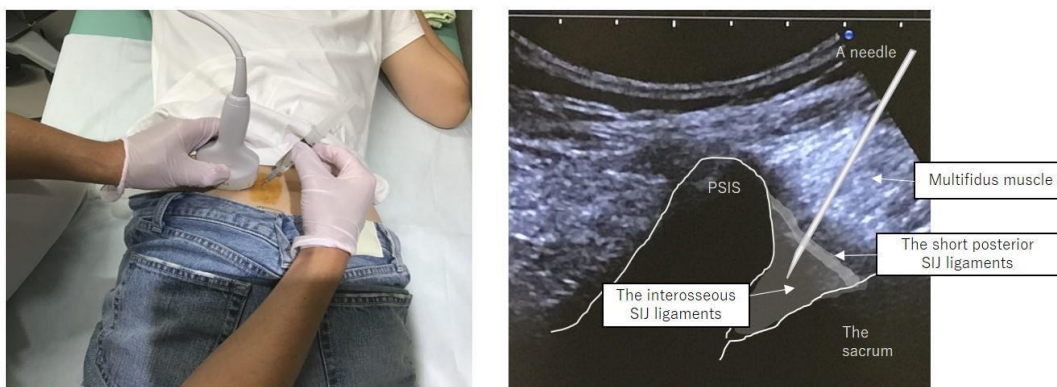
Ultrasound-guided periarticular SIJ injections
